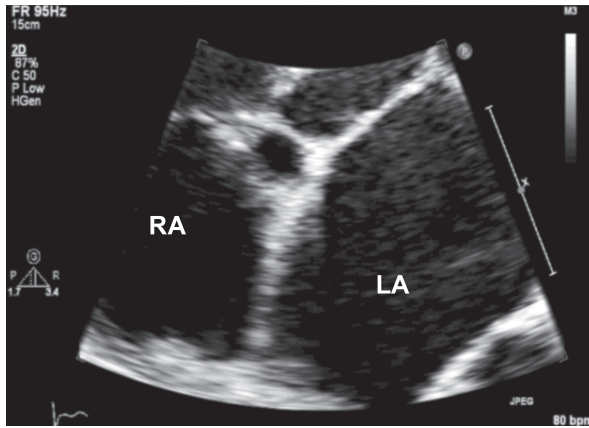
Two-dimensional transesophageal echocardiography shows thrombus (arrow) attached to the interatrial septum.
